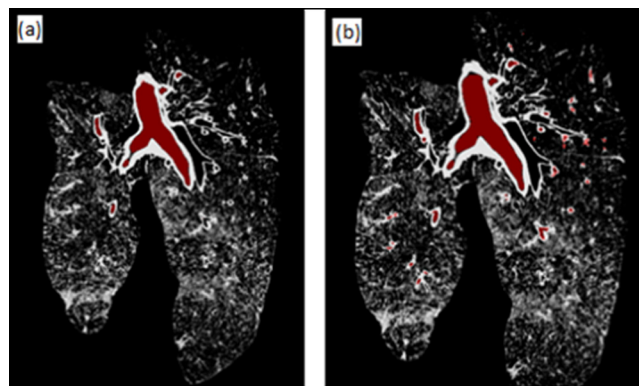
(Color online) Lung CT images used for segmentation: (a) Airway network 1, (b) airway network 2.
